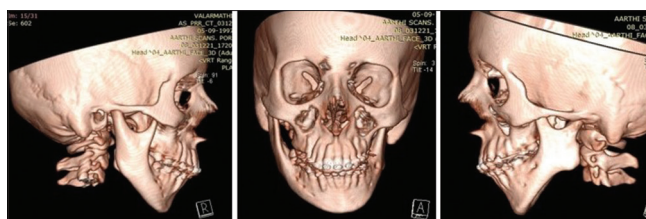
Three-dimensional reconstruction of computed tomography
